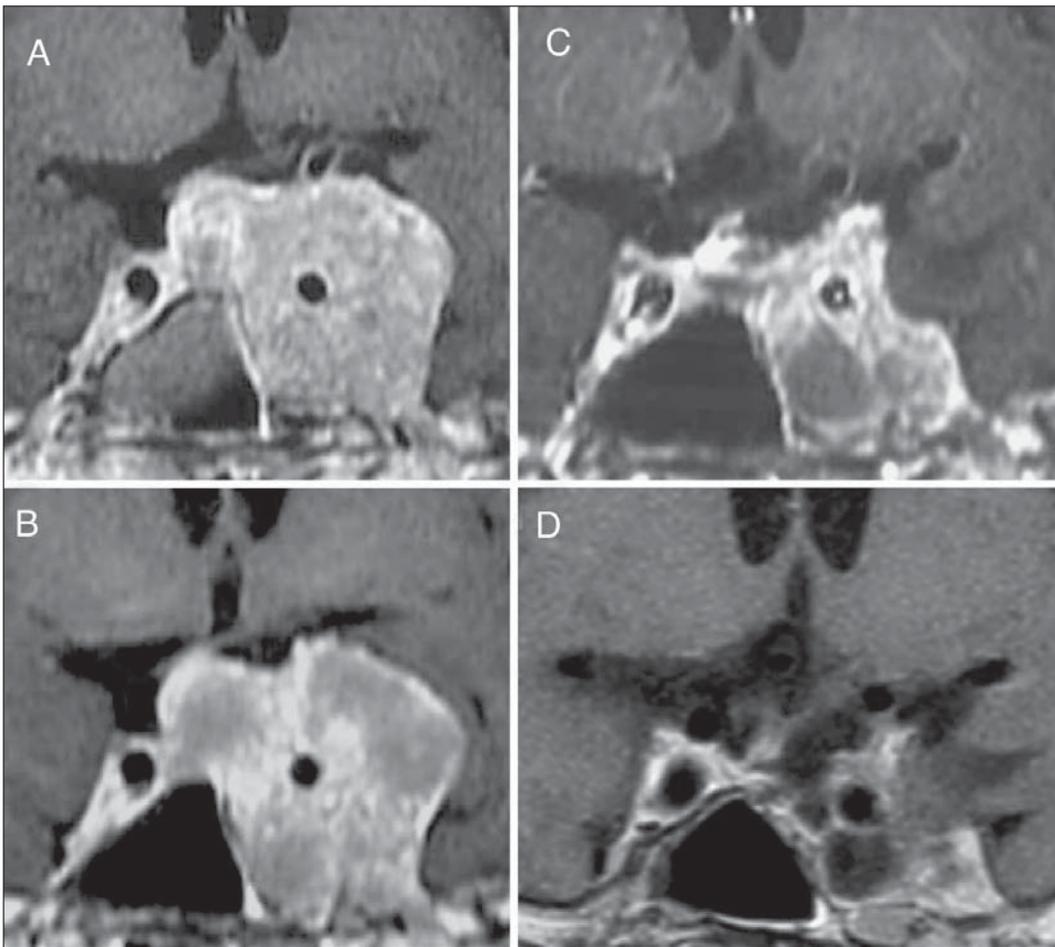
Case 4 with a clinically non-functioning pituitary adenoma. Sequential gadolinium-DTPA enhanced coronal MR images obtained before- (A), and 23- (B), 54- (C), and 131 months (D) after conventional radiotherapy. The tumor continued to grow during the first 23 post-treatment months and then its size decreased remarkably at 23 to 54 months after radiotherapy.
